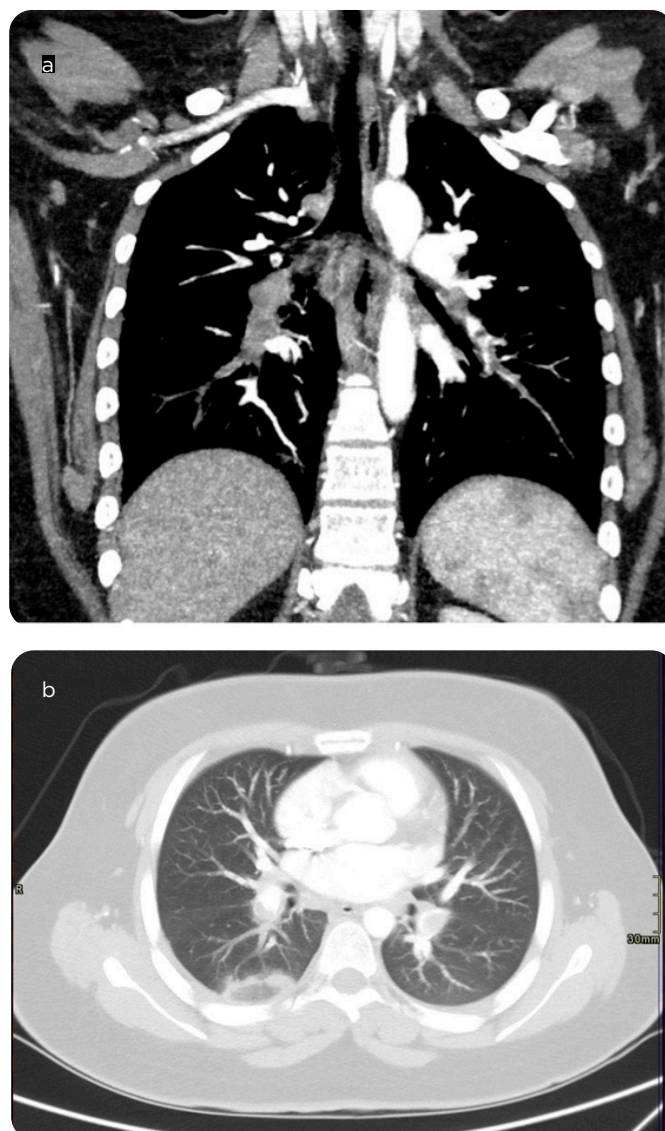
Chest CT angiography in a 35-year-old patient with syncope. a) coronal section in mediastinal window and b) axial section in lung window, showing bilateral lobar and segmental PE. Reverse halo sign of subpleural location in the apical segment of the right lower lobe due to pulmonary infarction, without other opacities suggestive of viral pneumonia.
